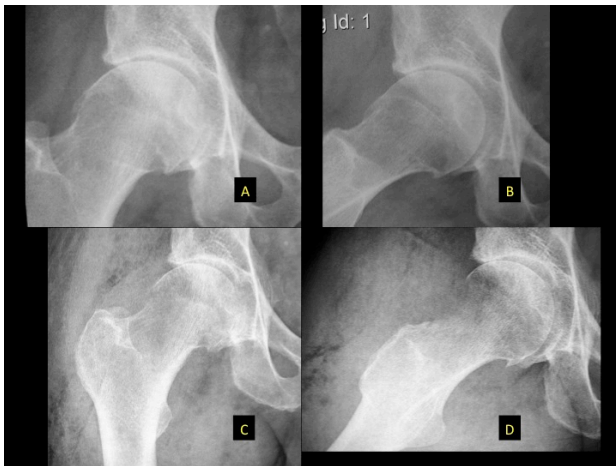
X-ray of a case with Tönnis II. A: Frontal view with advanced narrowing of femoroacetabular space. B: Axial view with abnormal alpha angle. C and D: Frontal and axial postoperative view with correction of impingement and alpha angle corrected.
